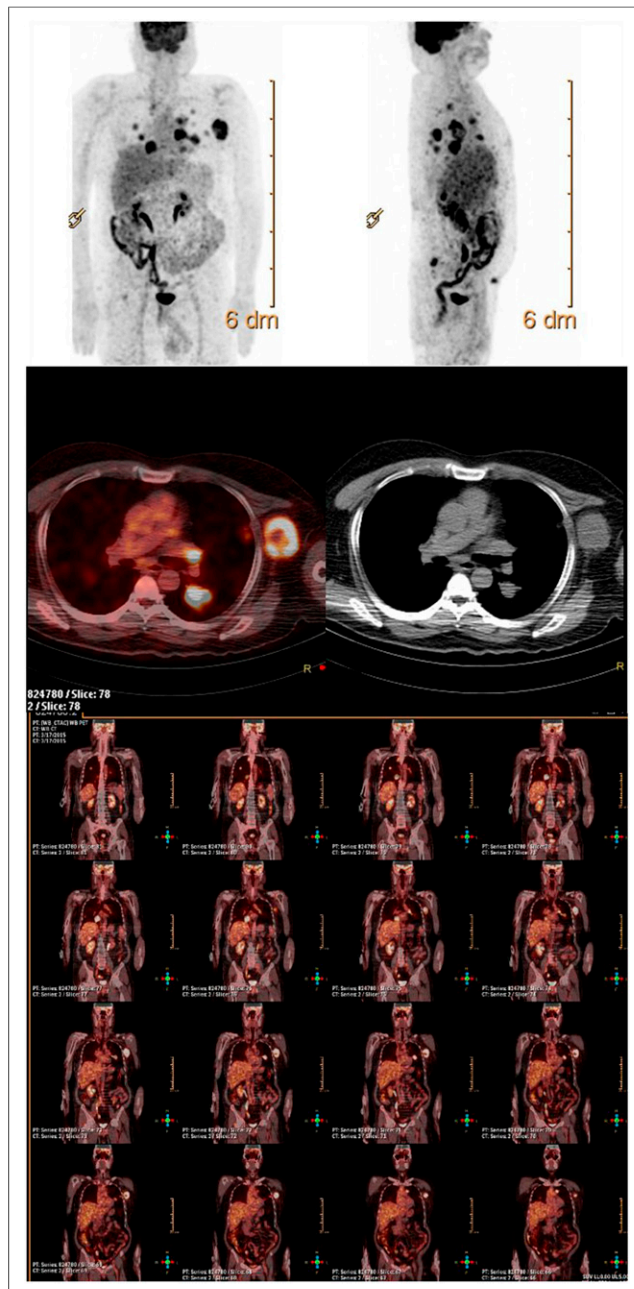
Maximum-intensity-projection (top), transaxial (middle), and coronal (bottom) ^{18}F -FDG PET/CT images showing high uptake in lung, soft-tissue, subcutaneous, and iliac lesions.
